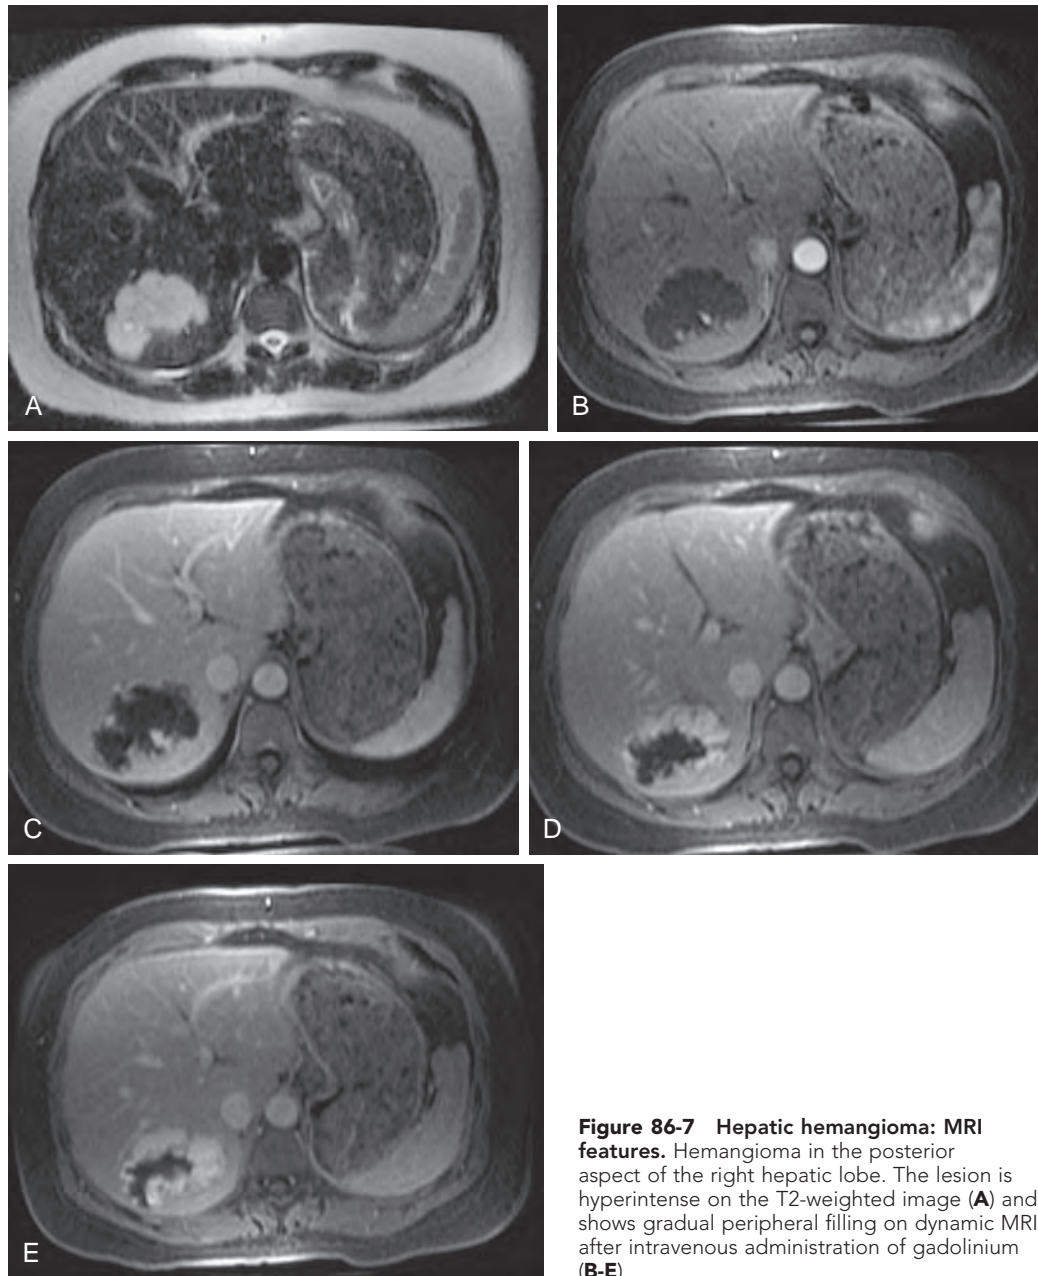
Hepatic hemangioma: MRI features. Hemangioma in the posterior aspect of the right hepatic lobe. The lesion is hyperintense on the T2-weighted image (A) and shows gradual peripheral filling on dynamic MRI after intravenous administration of gadolinium (B-E).
